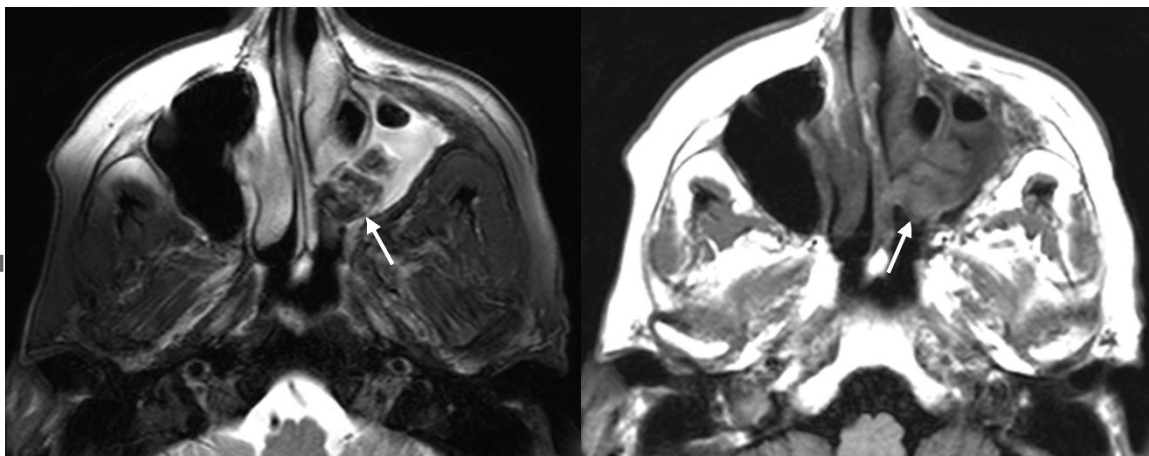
82-year-old female with a fungus ball in the left maxillary sinus. T2-weighted image (A) shows a nodular structure with low signal intensity in the left maxillary sinus (arrow), consistent with a fungal ball. T1-weighted image (B) shows the fungal ball with high signal intensity (arrow).
